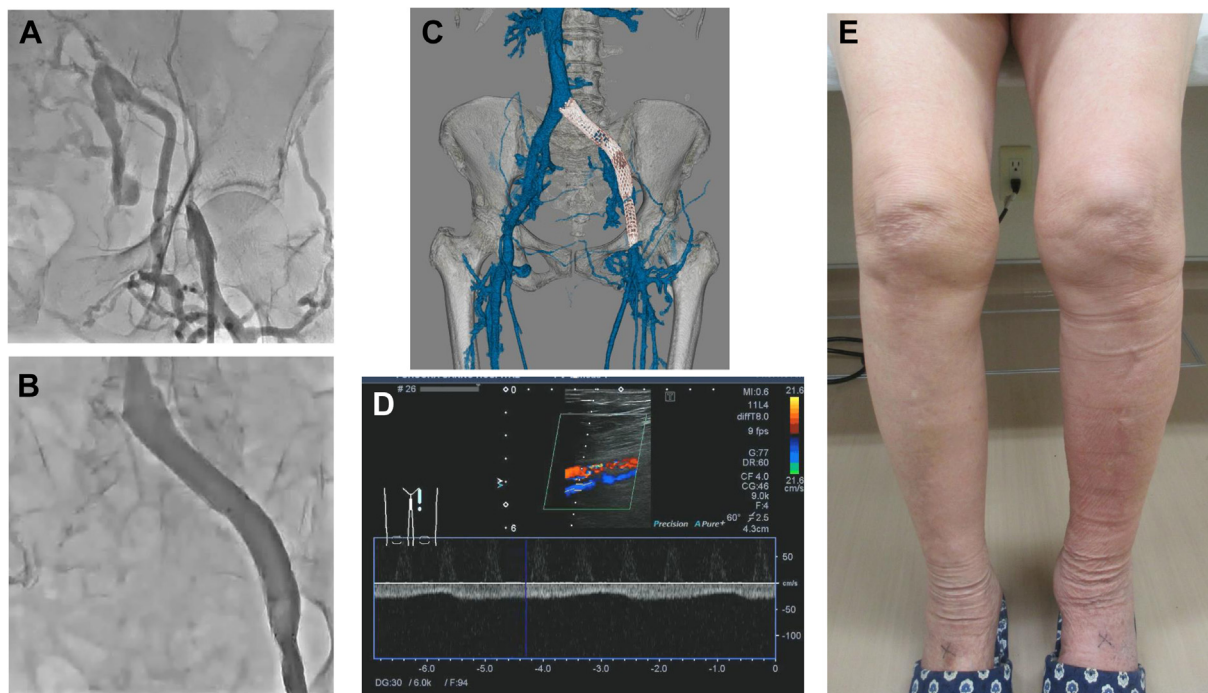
Operative and postoperative data of case 1. A, Venography before stenting showed occlusion of the left iliac veins with highly developed collateral vessels. B, Venous stenting (VS) was performed in the left common iliac vein (CIV), external iliac vein (EIV), and common femoral vein (CFV). The developed collateral vessels were undetectable. C, Computed tomography (CT) angiography three-dimensional reconstruction (venous phase) showing patent venous stent with decreased collaterals. D, Postoperative ultrasound examination showed blood flow of the left CFV with a venous waveform. E, Postoperative photograph. No swelling was observed in the left lower extremity.
